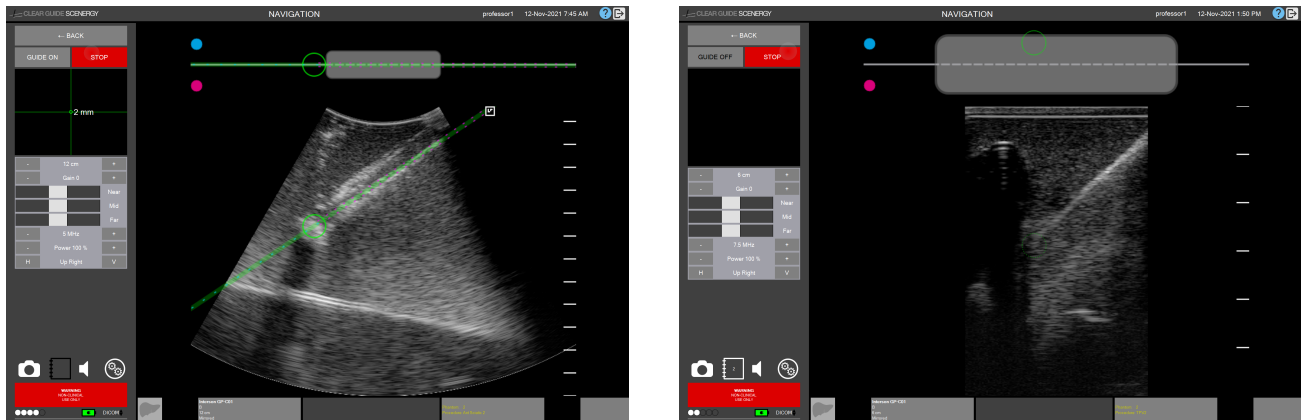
Left: The EDU system displays the ultrasound image with a pre-selected target and guidance information overlaid. Left: Guidance information displayed. Right: Guidance information hidden; the target remains visible.
